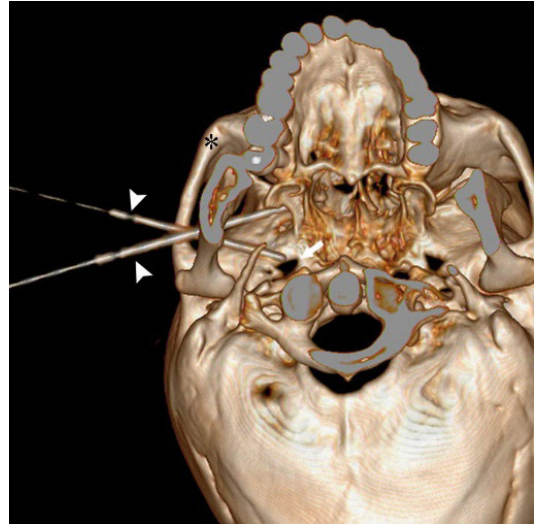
The 3D reconstruction CT showing the position of needle (White arrowhead). White arrow: foramen ovale (FO). * zygomatic.
